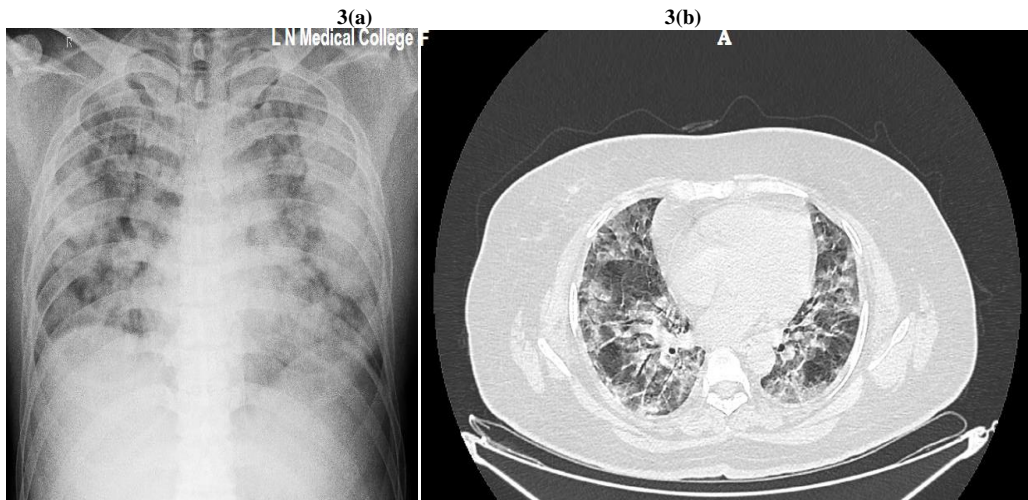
(a)-Chest radiograph of 17yrs old RTPCR positive patient showing GGO in bilateral upper, middle, and lower zone. 3(b)-HRCT of same patient showing multiple discrete and confluent patches of GGO and consolidation seen in both lung. CT severity score; 30(Severe lung involvement).
